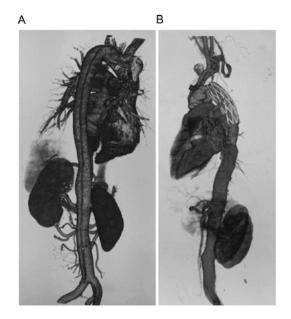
CTA of the aortic vessels of the proband. (A) CTA confirmed the formation of aortic dissection. (B) CTA image of the artificial vessel of the proband after Bentall surgery. CTA, computed tomography angiogram.
